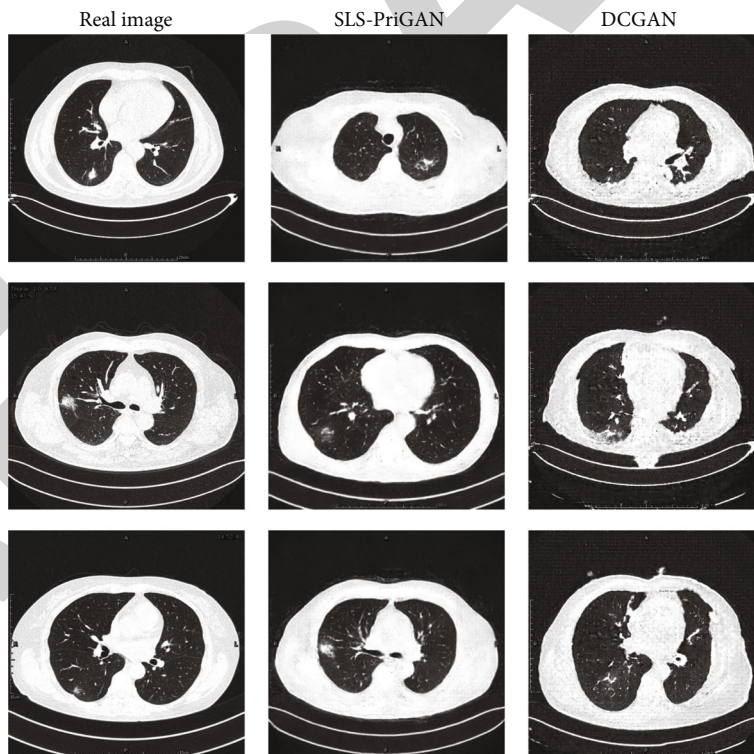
The generated result comparison with real CT images and DCGAN images.
